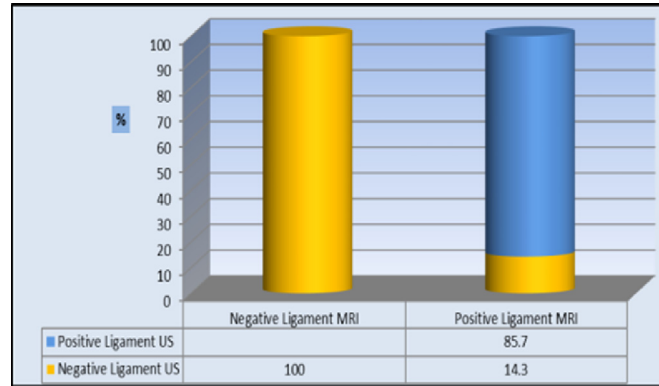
Representing ligamentous injury results diagnosed by ultrasonography.
